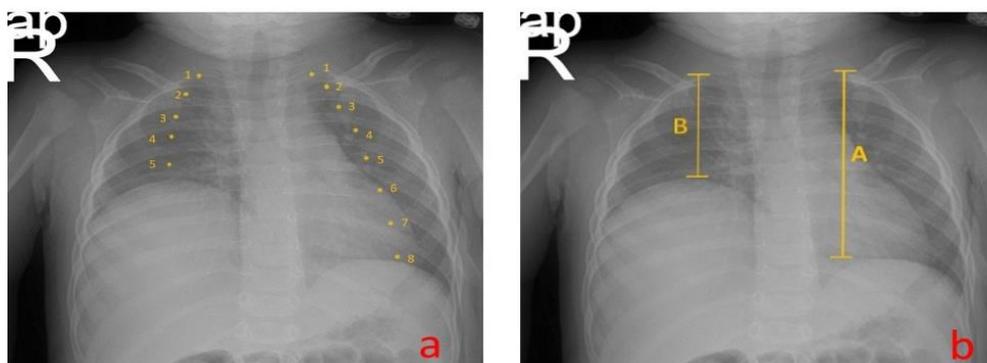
Evaluation of eventration level on chest radiographs. a) Measuring the intercostal distances b) Measuring the distance between the peaks of the hemidiaphragm and apex.
